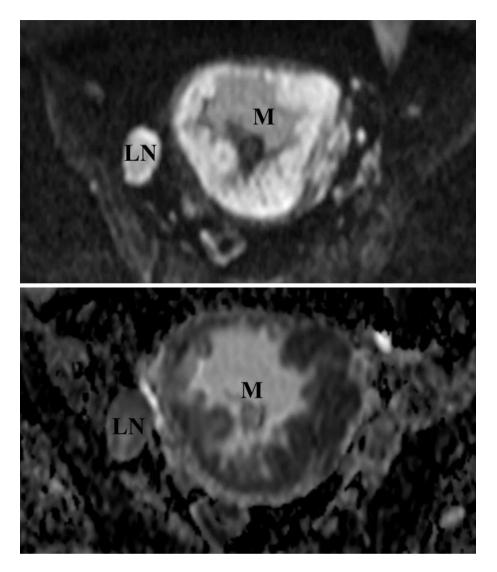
Diffusion weighted MRI (A) showing high signal intensity involving a large metastatic right internal iliac chain lymphnode (LN) and cervical mass (M) which on corresponding ADC mapping (B) image showing restricted diffusion.
